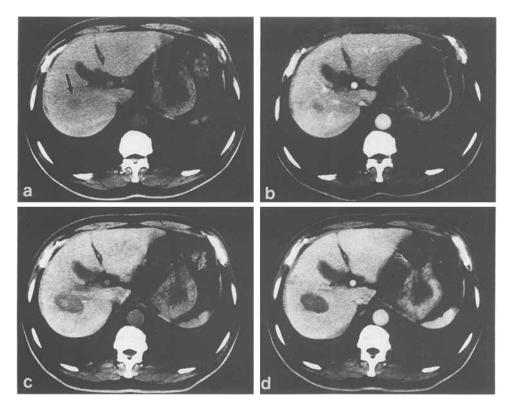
(Patient 14): Plain CT (a and c) and CE-CT (b and d). (a and b) Before treatment. The tumor site (black arrow) is S7. (c and d) One week after treatment. After treatment, the tumor and the surrounding area showed decreased density and were not enhanced.
